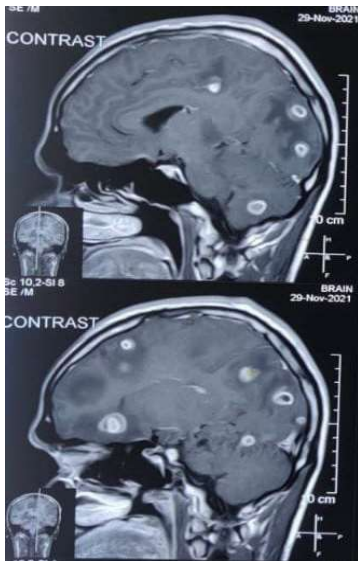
Sagittal T1 weighted MRI of the brain shows multiple tuberculoma.
